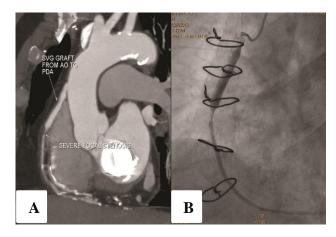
Stenosis in mid segment of SVG graft to PDA. (A): MPR image of CT, (B): Corresponding catheter angiography image.
